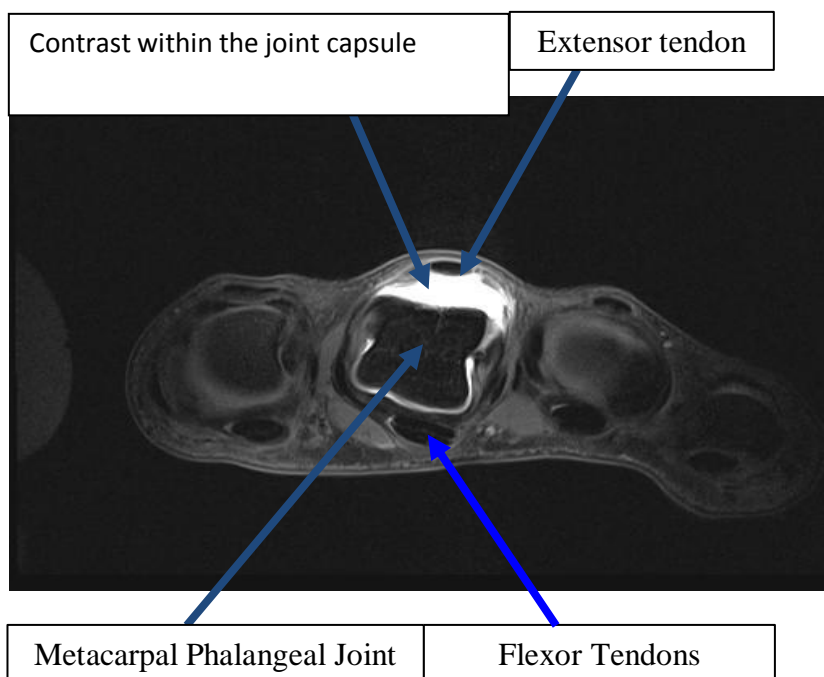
3T MRI scan of Metacarpal Phalangeal Joint
